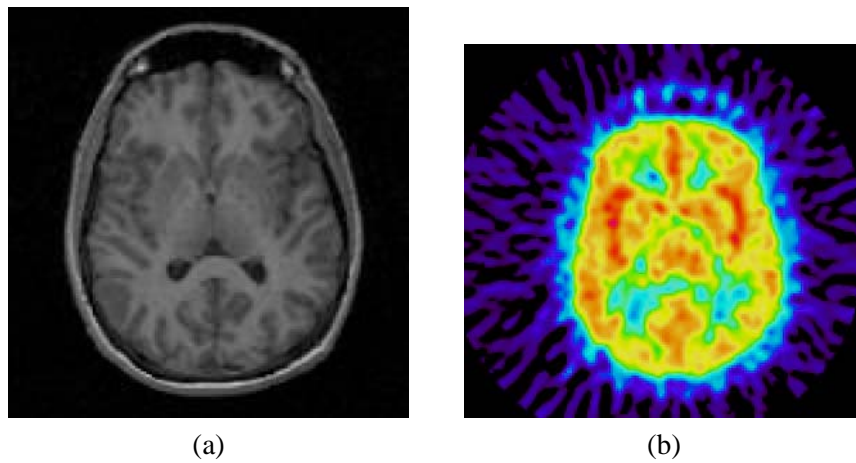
The original a) MRI and b) PET volumes. See page 66 for a colour version of the figure.
